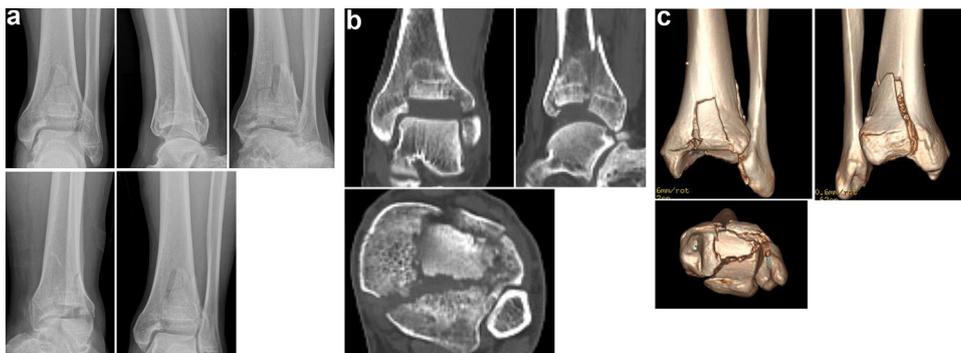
Imaging studies given for the survey. Plain radiographs (a), 2D computed tomography (b), and 3D computed tomography (c) of the pilon fracture given for the survey.
